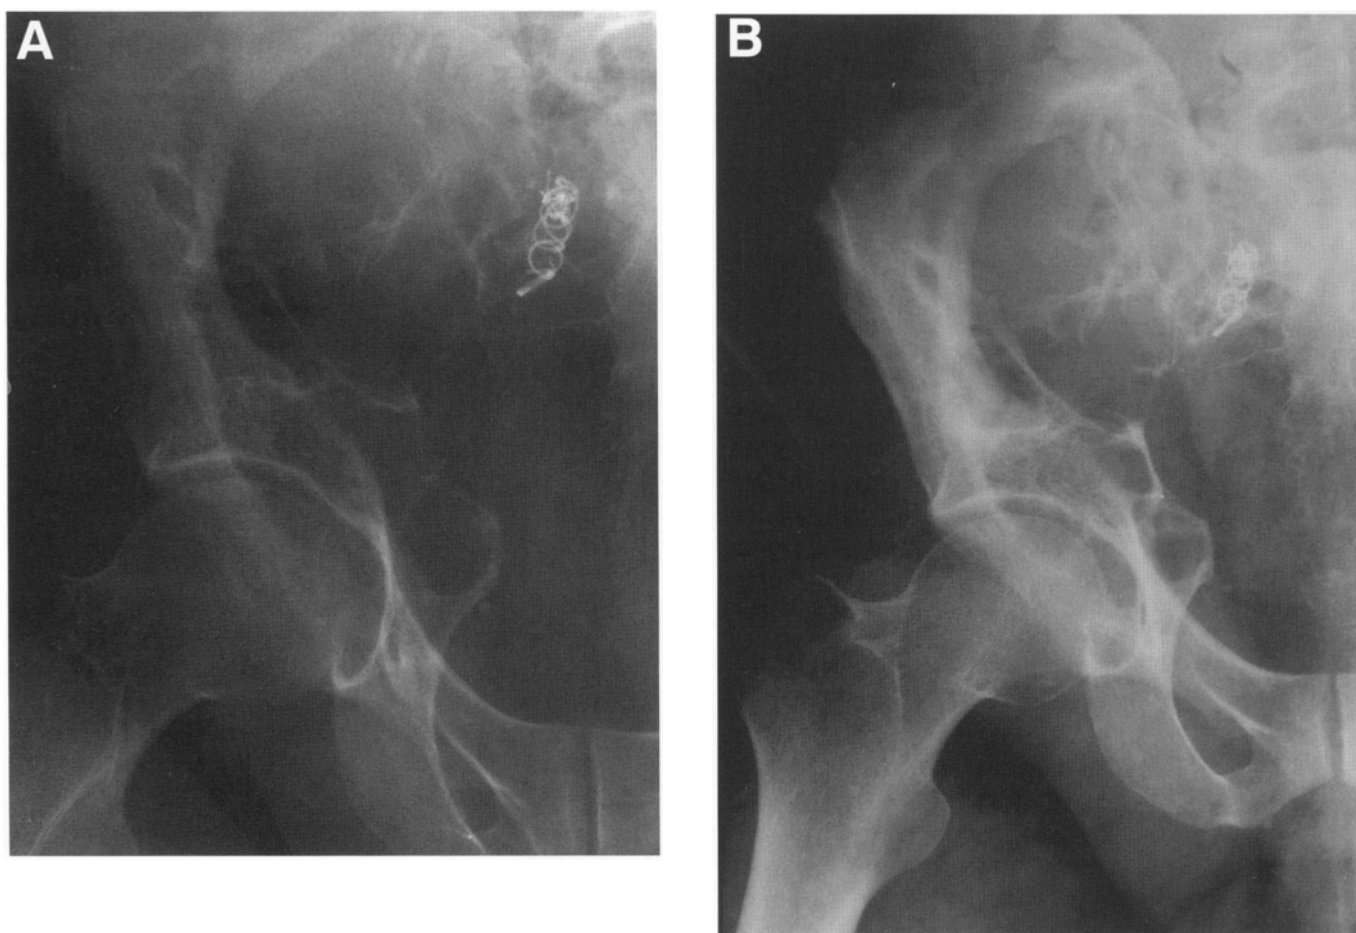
A 45-year-old patient presented with excruciating right flank and sciatic pain. Plain radiographs revealed a large destructive lytic lesion of the innominate bone, and staging studies revealed a right renal mass and showed that the sacral lesion crossed the midline to the contralateral sacral foramina. The significance of that finding is that even extended hemipelvectomy would not achieve tumor-free surgical margin. CT-guided core needle biopsy of the sacral lesion established the diagnosis of metastatic hypernephroma and embolization was performed with near-complete resolution of pain after 36 hours. (A) Plain radiograph, performed 24 hours after the procedure (note the coil); and (B) after 6 weeks. Note the thick sclerotic rim of bone in the periphery of the lesion, which is the response of the host bone and indirect evidence of a significant decrease in tumor progression.
